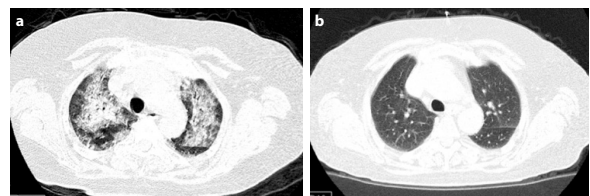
(a) HRCT image before treatment. (b) Control image after treatment
